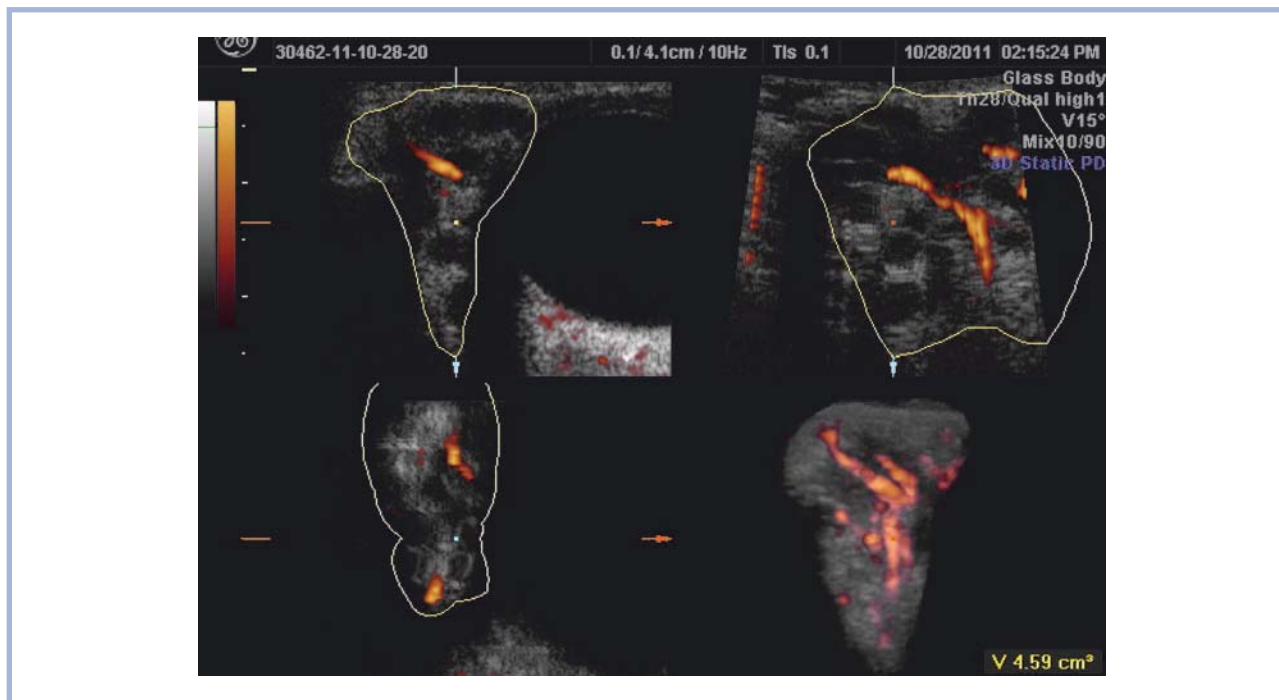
Multiplanar spatial ultrasonic analysis of a combined 3D reconstruction of an altered lacrimal gland (explanation in the text).
